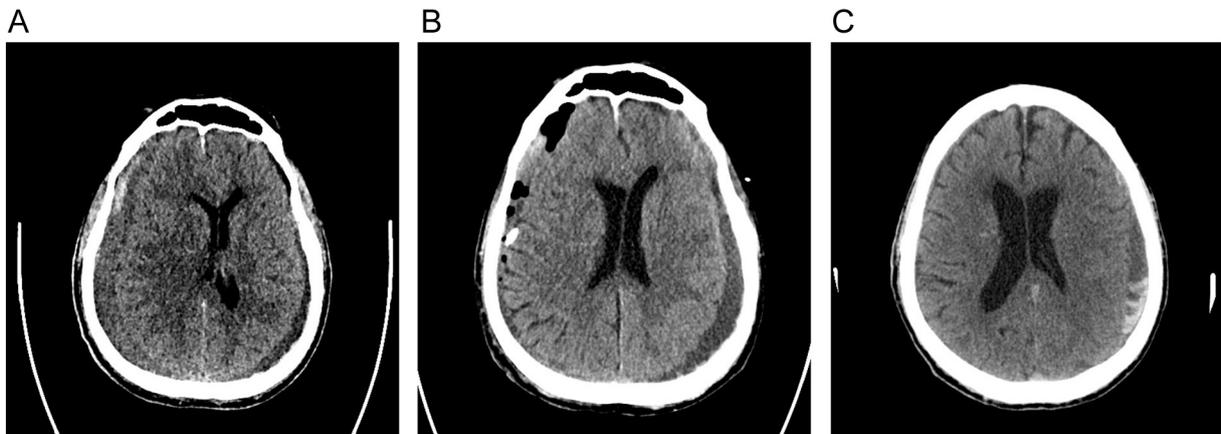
Imaging from case 3. A: Pre-operative axial CT image demonstrating bilateral mixed attenuation SDH with mass effect on the right hemisphere and right to left midline shift. B: Post-operative CT demonstrating SDD with decreased size of right side SDH with decreased mass effect and shift. There is moderate pneumocephalus. The left SDH is slightly larger. C: 1-month follow-up CT demonstrating very small residual right SDH and stable left SDH.
